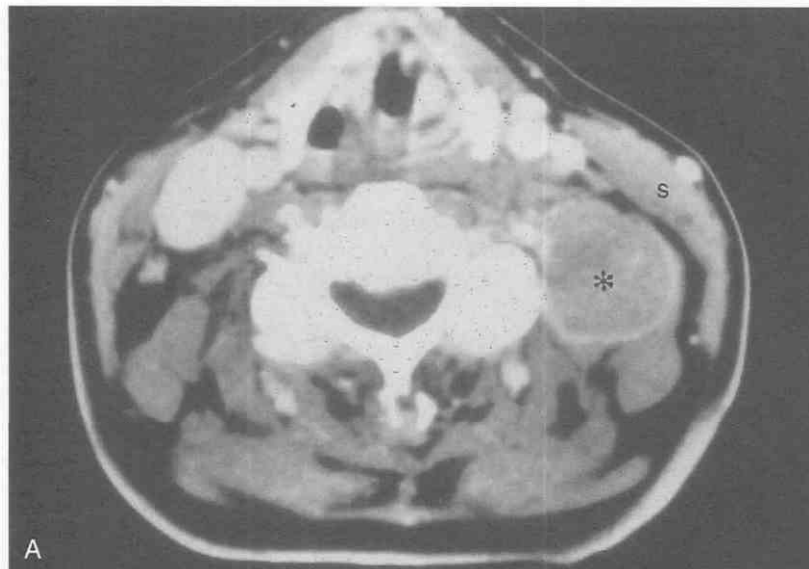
Dorsal cervical nerve root schwannoma. *A*, Axial contrast-enhanced CT scan at the level of the thyroid cartilages demonstrates a rim-enhancing solid posterior triangle mass (*asterisk*) deep to the left sternocleidomastoid muscle (*S*). On this single image, differentiation of neural tumor from enhancing lymph node would be impossible. *B*, Axial contrast-enhanced CT scan at the level of the hyoid bone demonstrates that the mass (*asterisk*) involves the neural foramen (*arrows*), allowing the correct radiologic diagnosis of neural tumor.
